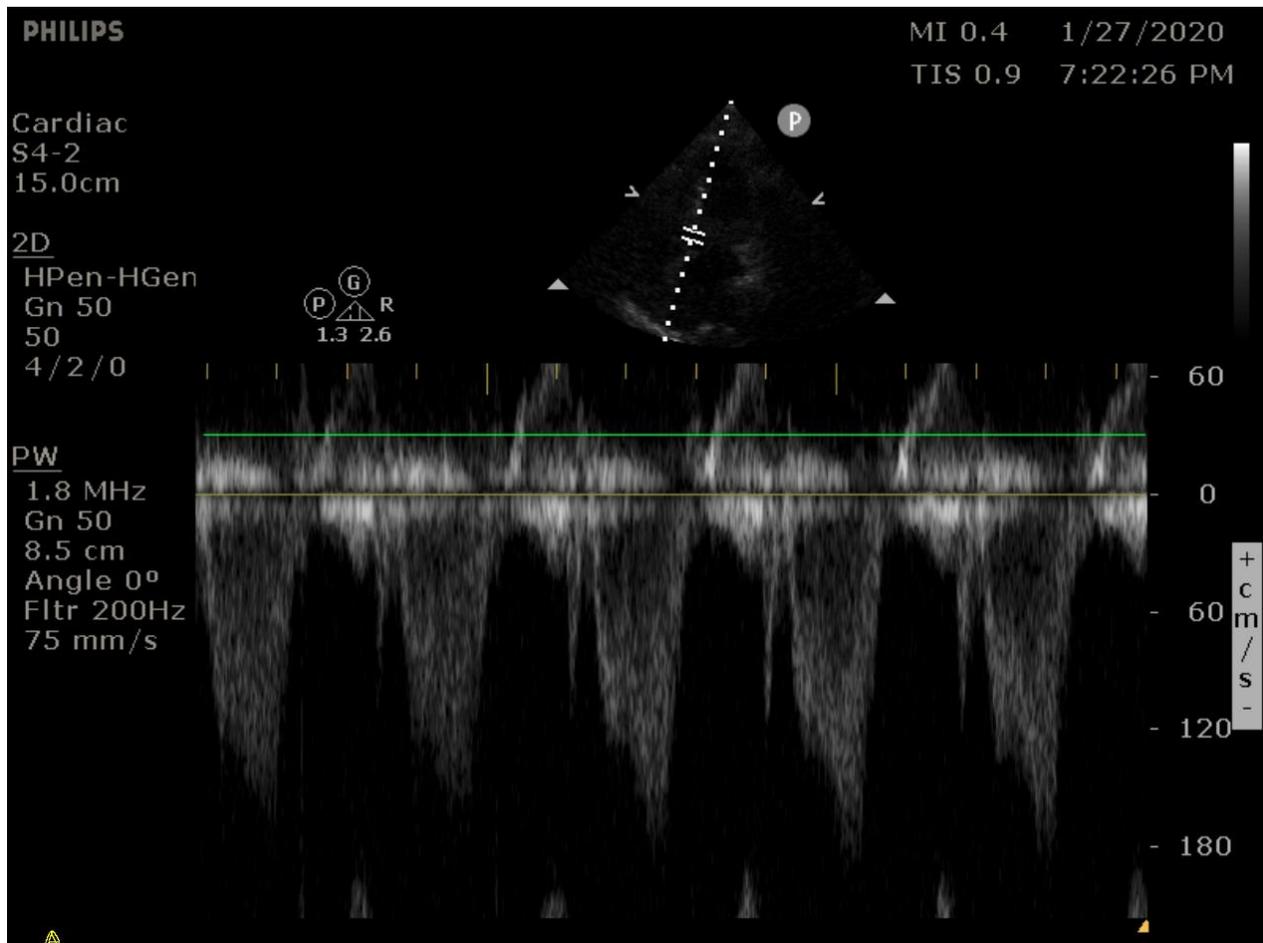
Intraoperative point-of-care ultrasound cardiac exam
